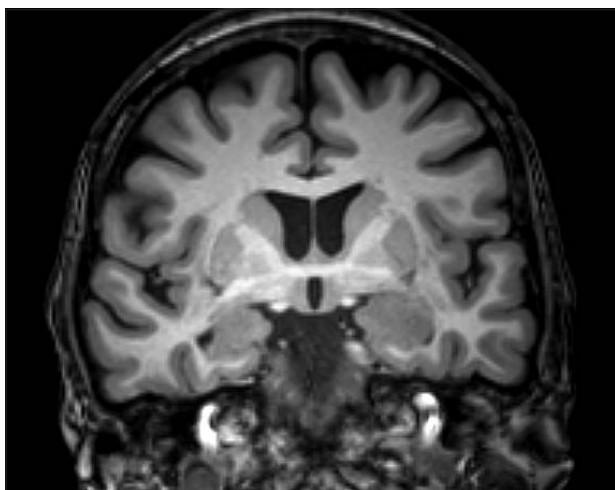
Brain MRI showed an increased signal and volume of the left uncus, hippocampal crus, dentate gyrus, and amygdala
